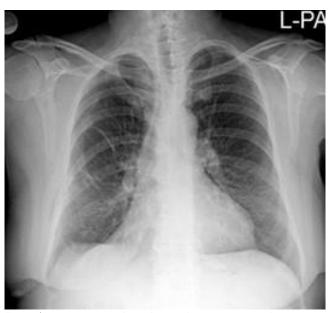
Postoperative 3rd-month control Postero-anterior chest x-ray
